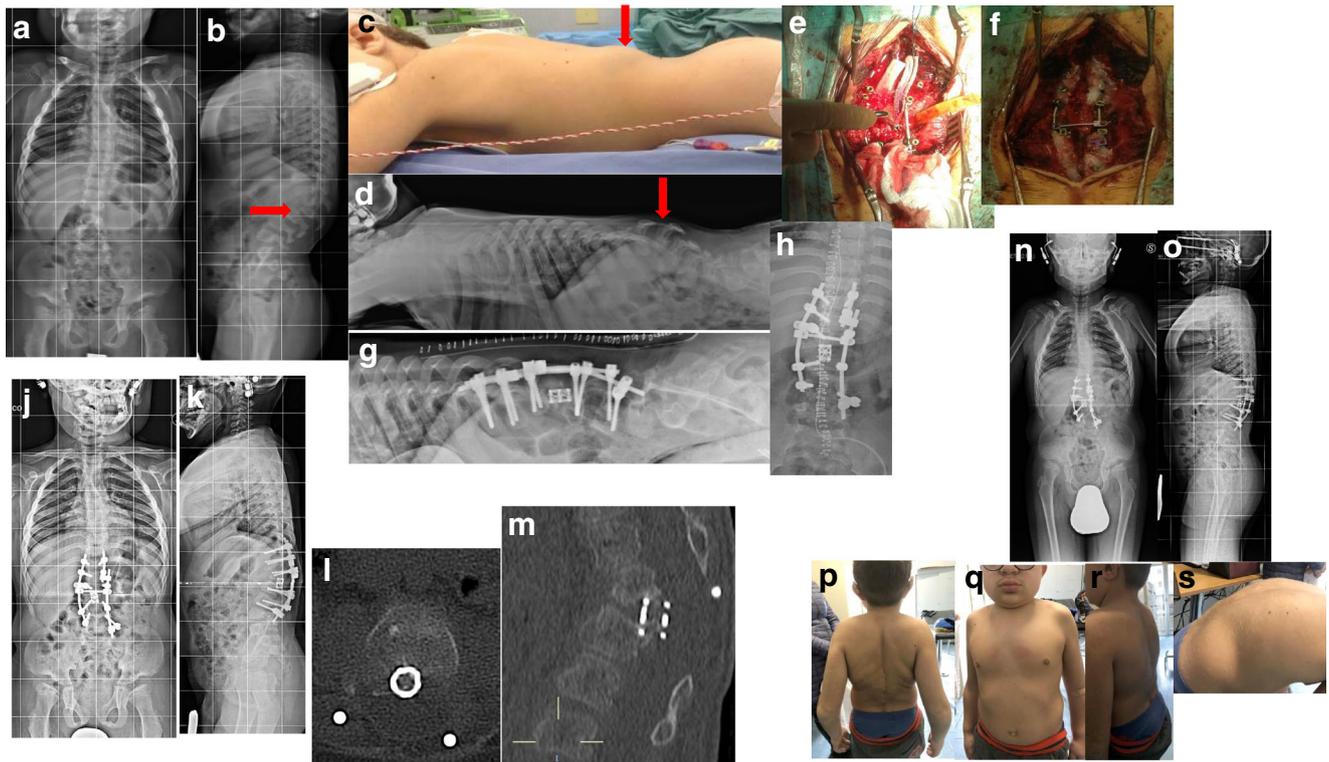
C.R. 6-year-and-1-month-old a and b standing radiographs; c and d thoracic lumbar “hump,” kyphosis is fixed and very stiff and does not modify in prone position; e and f intervention: provisional stabilization rods were mounted and we proceed to complete L2 vertebrectomy by posterior access only: as L2 has been completely removed, the gap between L1 and L3 was filled by cage cut to measure, filled with autologous bone insert obtained from vertebrectomy; g definitive rods, adequately contoured to restore thoracolumbar lordosis, were applied obtaining progressive correction. T11-T12-L1 and L3-L4 posterior
